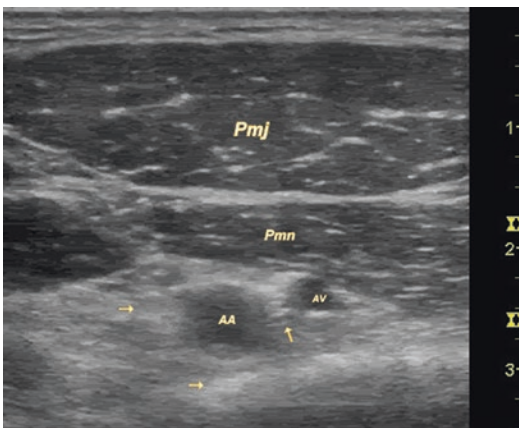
Ultrasound appearance of the approach to the infraclavicular nerve block. The pectoralis major (*pmj*) and pectoralis minor (*pmn*) cover the brachial plexus noted by arrows, which surrounds the axillary artery (*AA*). The small axillary vein (*AV*) is located caudal to the artery
